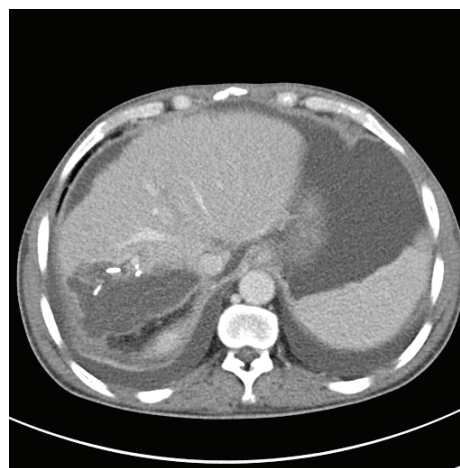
The same patient after the right hemihepatectomy. Computed tomography scan shows the irregular and encysted fluid collection in the tumor bed, measuring 80 × 52 × 42 mm, of 20 Hounsfield units (HU) density, suggesting a postoperative inflammation.
